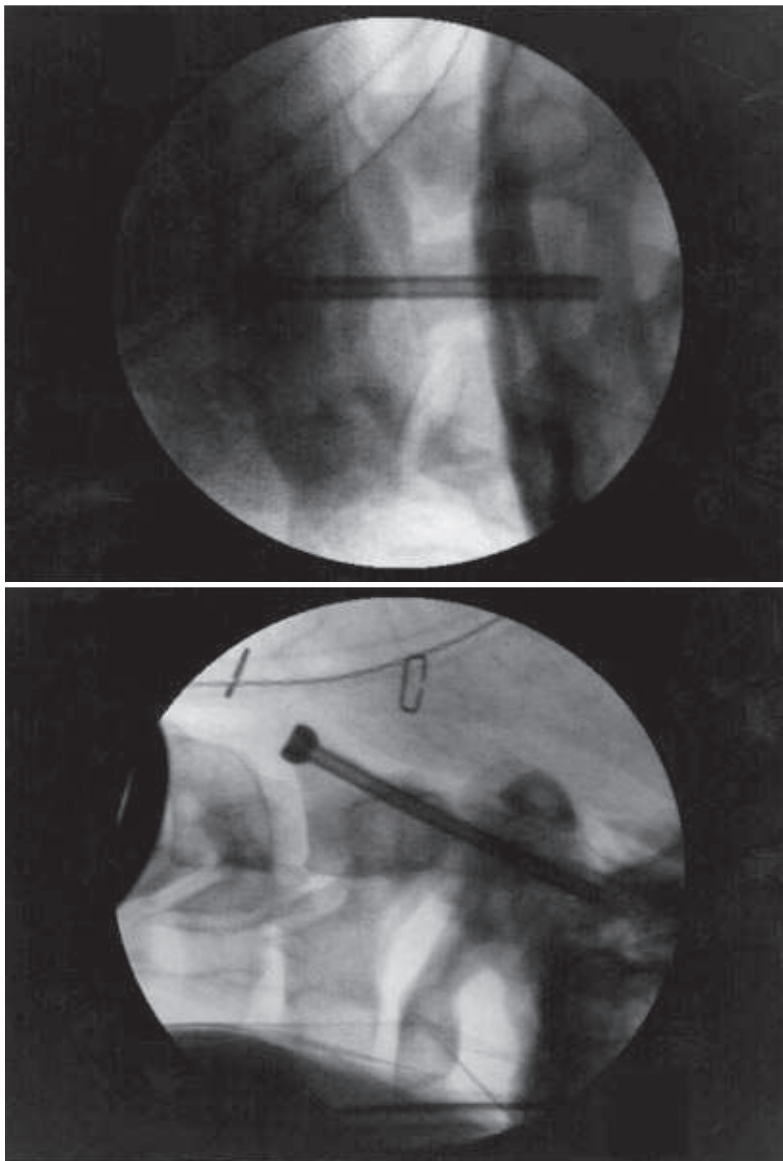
Final anterior and lateral radiographs showing good reduction and fixation of the odontoid process fragment.
